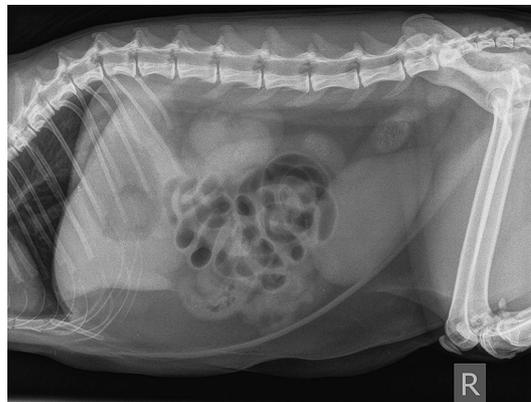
Right lateral abdominal radiograph shows prominent clumping of the small intestine and increased luminal gas.
